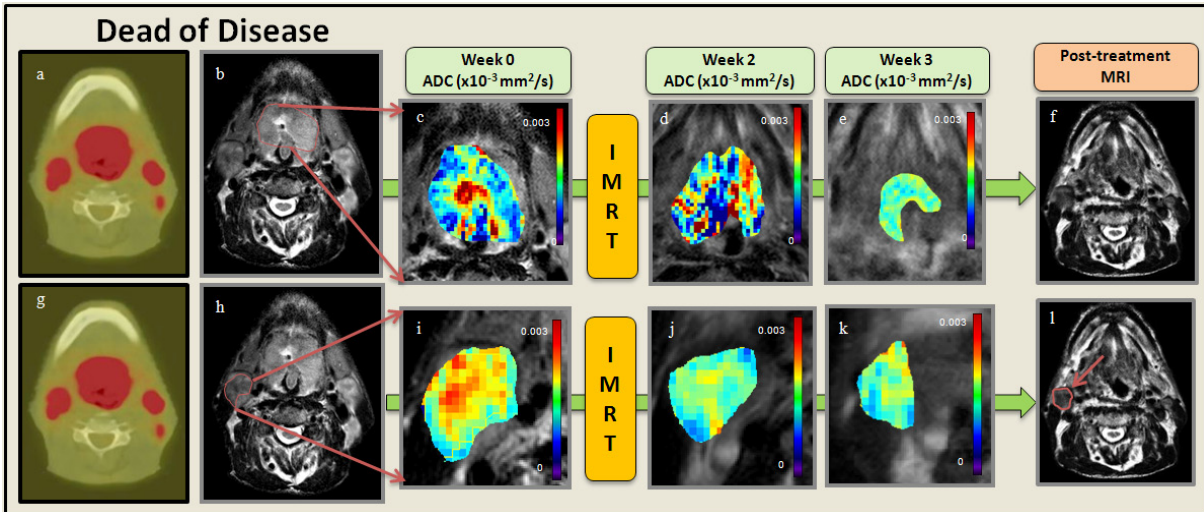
Representative DOD patient. a. and g. pre-Tx PET/CT of the primary tumor and three neck nodal metastases. b. and h. Primary tumor and representative neck nodal metastasis contoured over a T2W MRI. c. and i. pre-Tx ADC map overlaid on T2W MRI. d. and j. Wk2-Tx ADC map overlaid on T2W. e. and k. Wk3-Tx ADC map overlaid on T2W. f. and l. T2W MRI post-Tx with no evidence of primary tumor but with presence of neck nodal metastasis.
